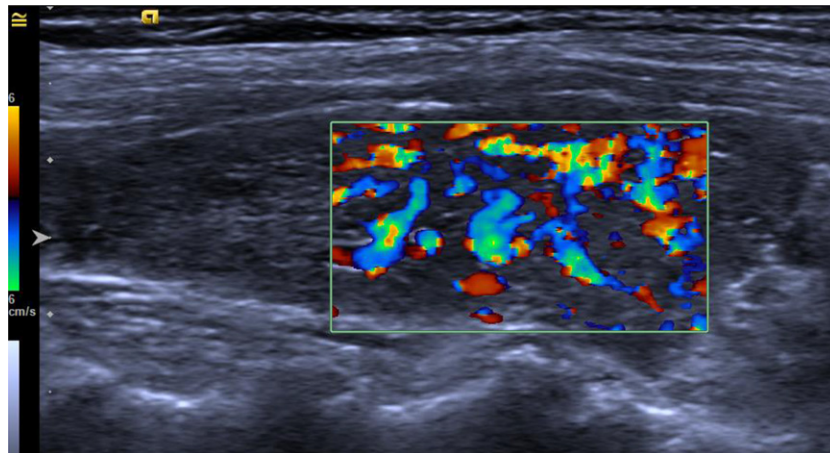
Graves' disease: echogenicity is reduced with irregular echostructure. A diffuse increase of parenchymal vascularization is observed at color-Doppler evaluation (right lobe, sagittal section).
